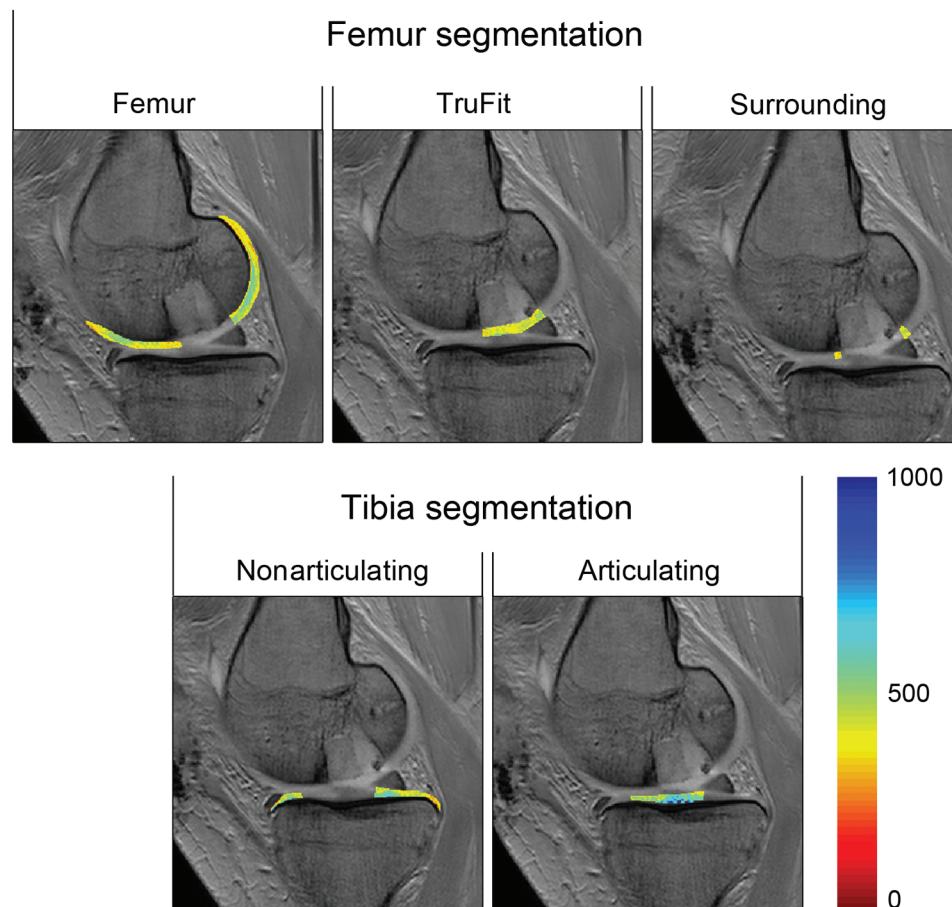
Regions of interest (ROIs). Sagittal magnetic resonance images of postoperative situation when an osteochondritis dissecans lesion of approximately 1.5 cm was treated using 2 TruFit BGS plugs. The bone-plug interface is clearly visible and could be used to define the ROIs. The color bar represents the calculated dGEMRIC index (T1gd), where a high T1gd (1000 ms) is depicted as blue and a low T1gd as red.
